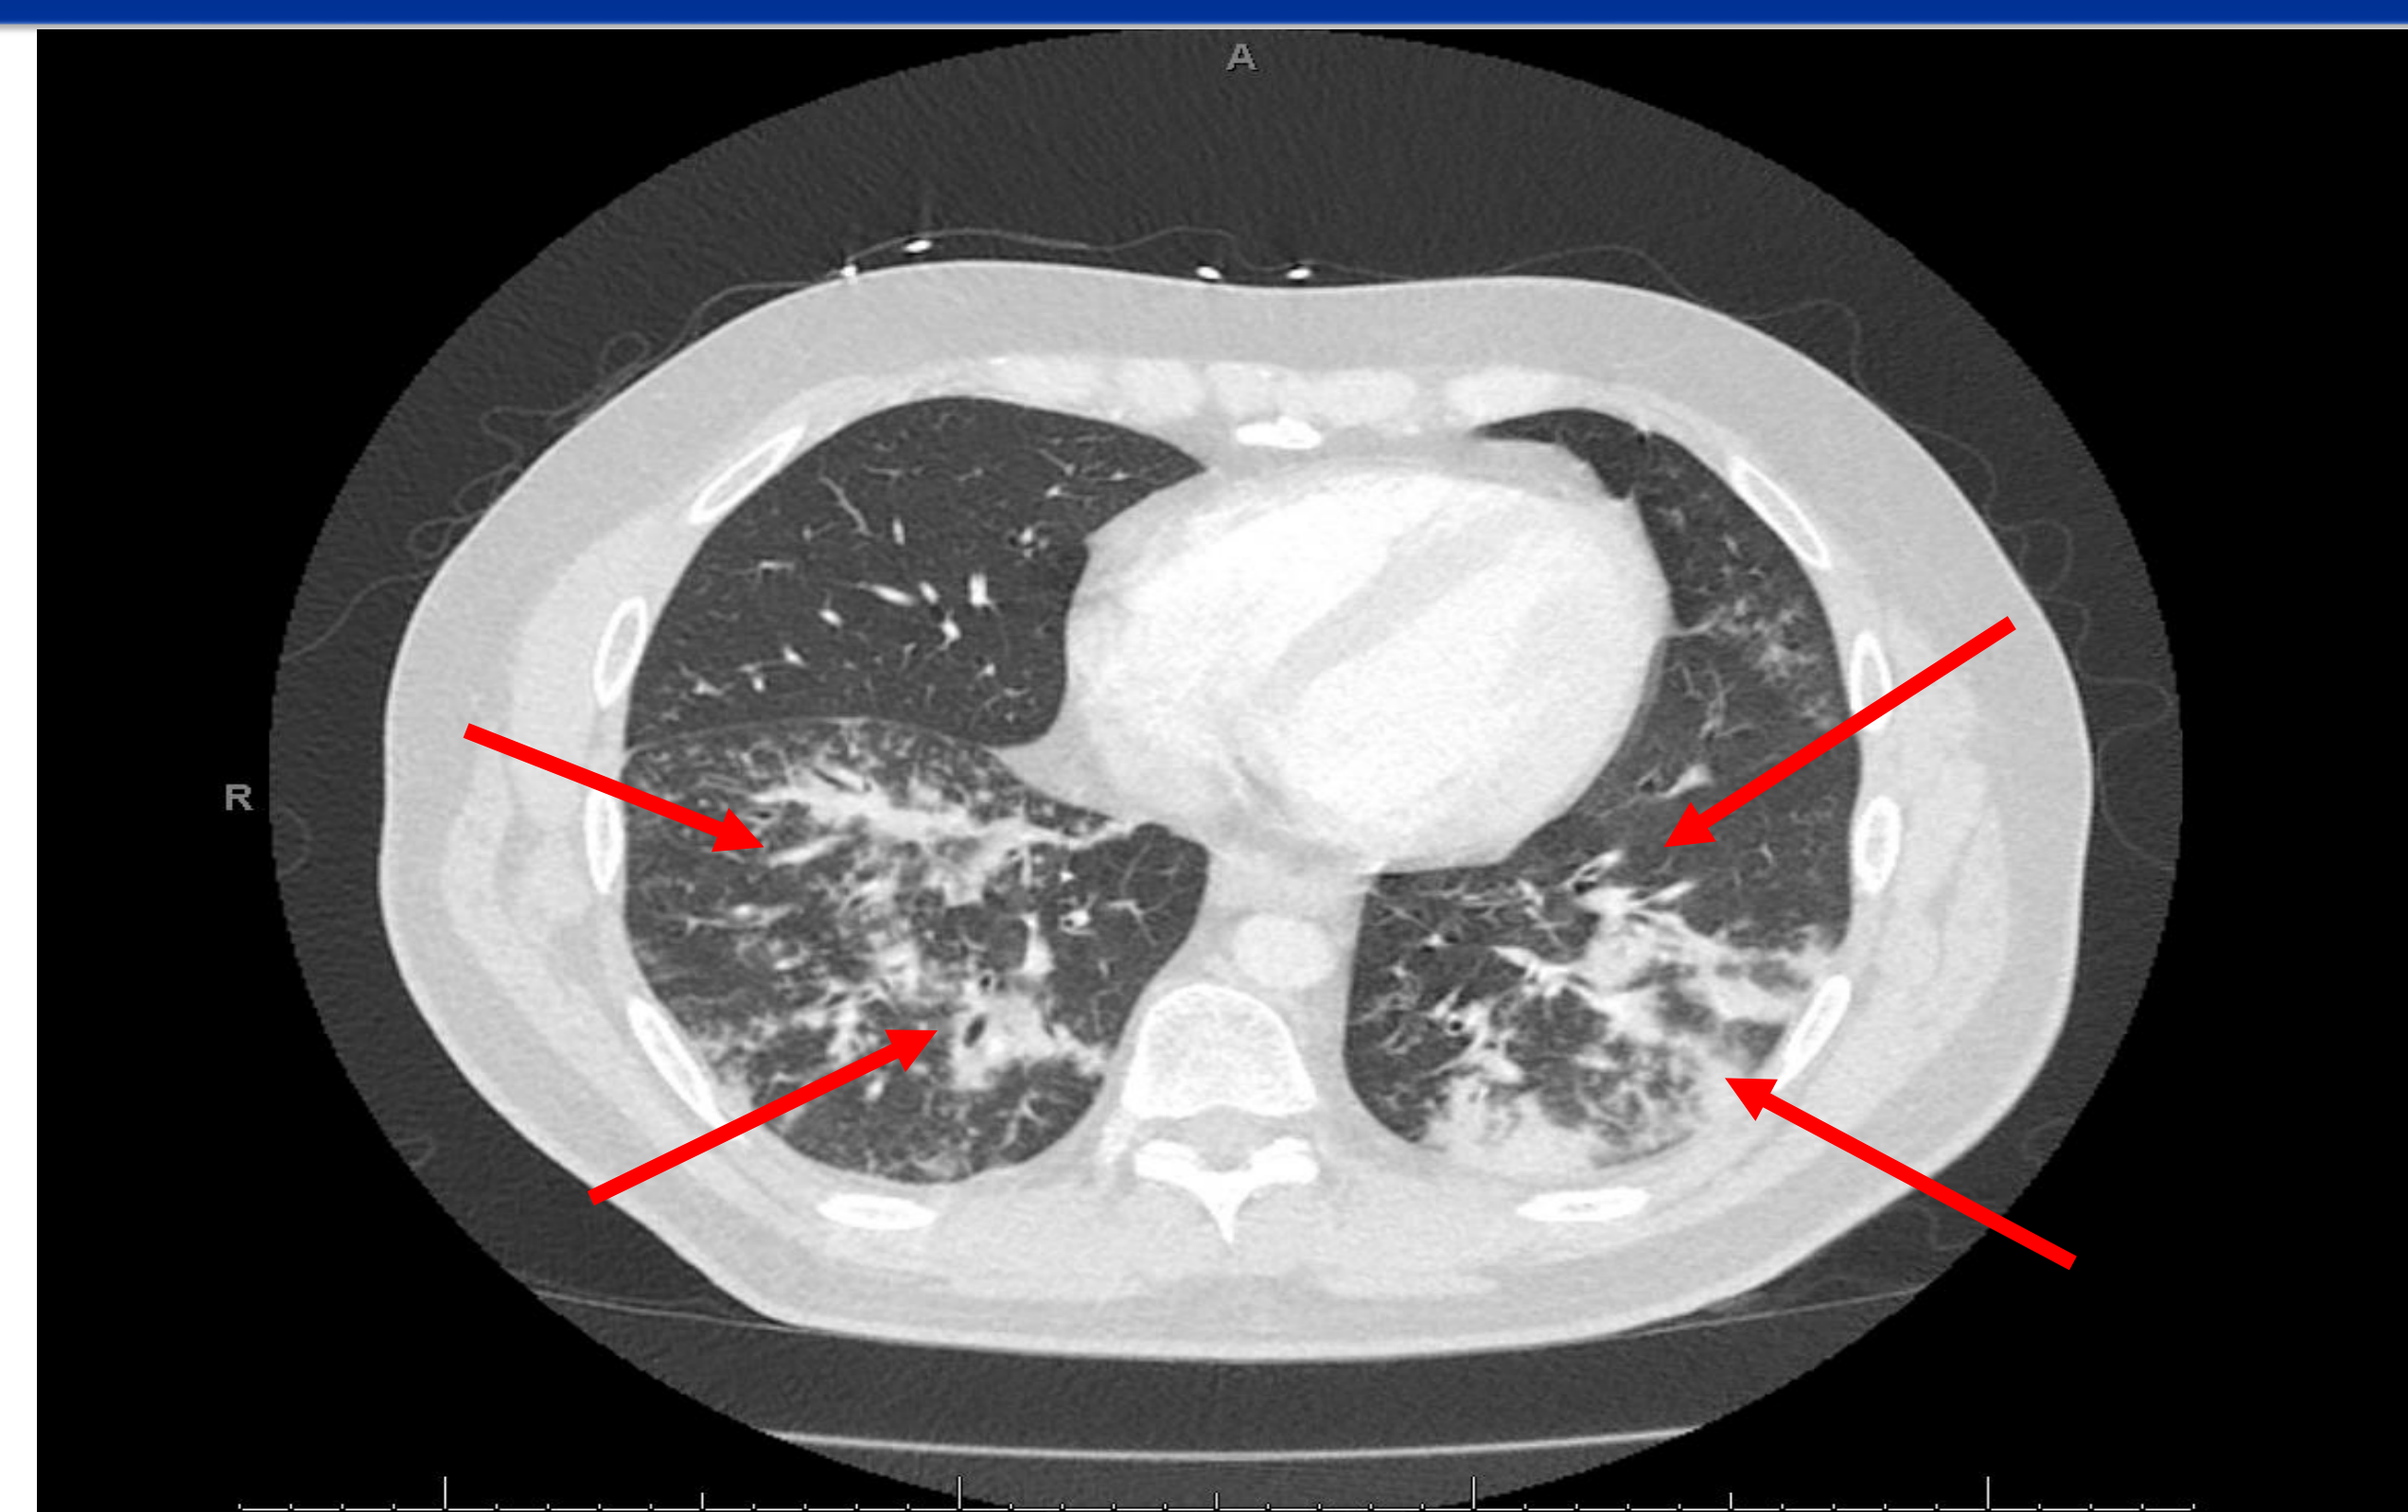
CT Chest with IV contrast; Horizontal Section. (Figure 1). Arrows pointing to lung infiltrates.
